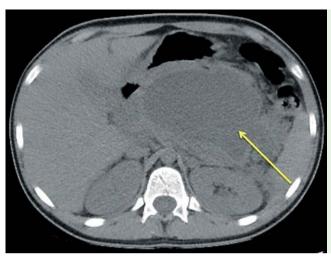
Computed tomography (CT) scan showing the pancreatic collection (arrow) abutting the stomach prior to endoscopic drainage.
